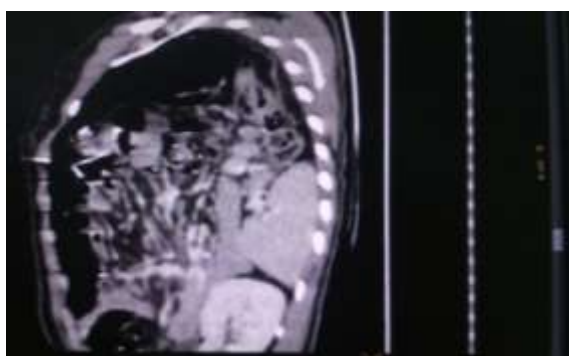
CT scan showing presence of mesentery, large gut, spleen, abdominal blood vessels in thorax
